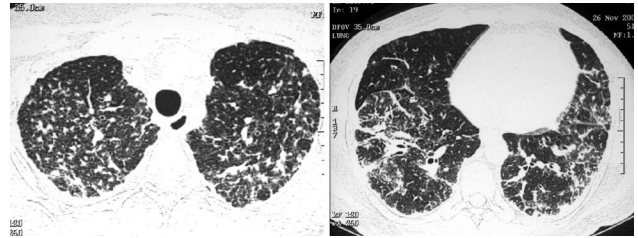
High-resolution computed tomogram shows peribronchovascular thickening, interlobular septal thickening, and septal nodules.
